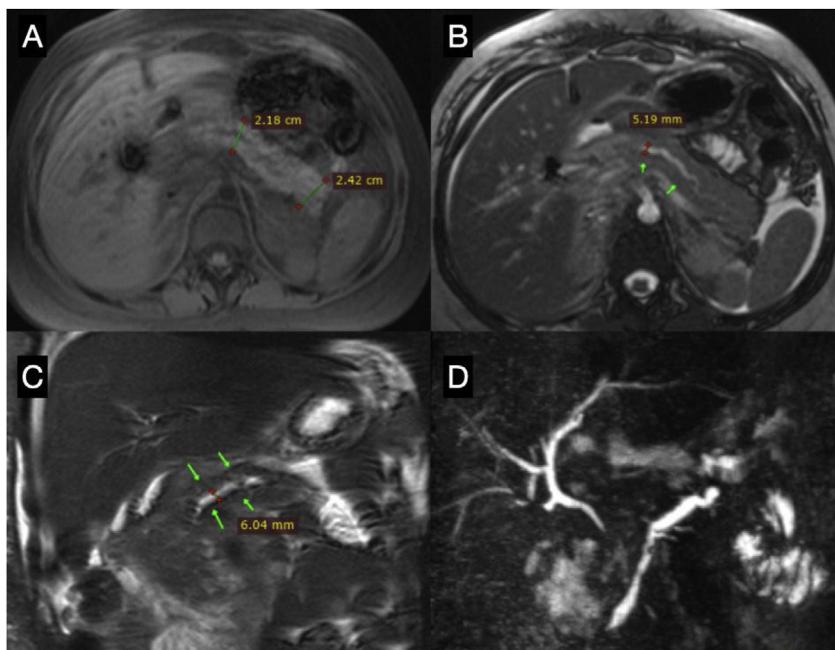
Magnetic resonance cholangiography. (A) T1-weighted axial view, showing the enlarged body and tail of the pancreas. (B) T2-weighted axial view, showing the body of the pancreas, with irregular dilation of the main pancreatic duct. (C) T2-weighted coronal view, showing the dilation of the main pancreatic duct. (D) MIP reconstruction of the cholangiopancreatography, showing irregular dilation of the main pancreatic duct and normal intrahepatic bile ducts.
